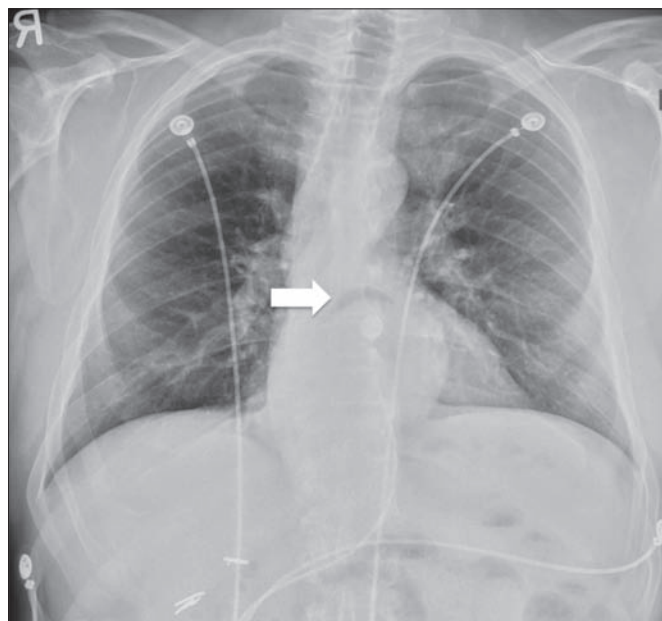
Chest x-ray demonstrating an air-fluid level, raising suspicion of an intrathoracic stomach.
